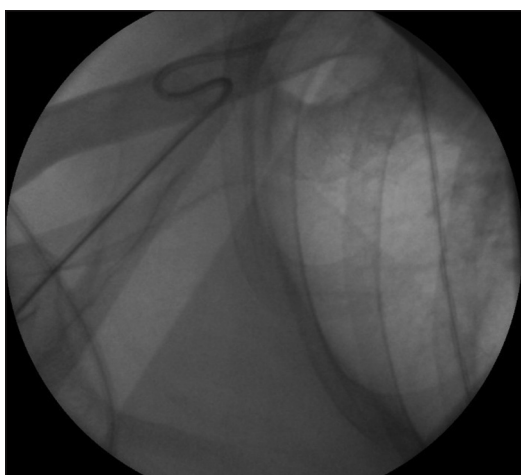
Chest radiograph showing catheter partially straightened with the guide wire inside it
